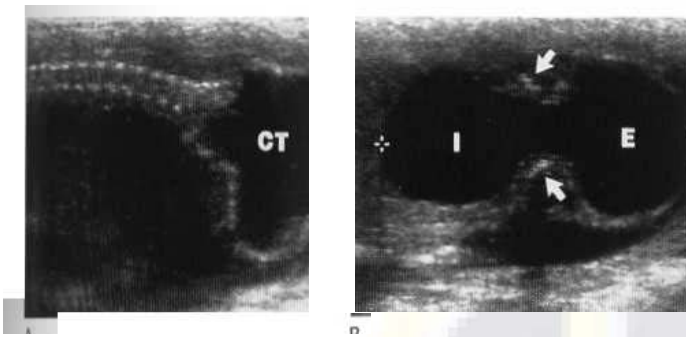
Sacrococcygeal teratoma: longitudinal (A) and transverse (B) images. CT = cystic teratoma at lower end of spine; f and E = intra- and extrapelvic components respectively; arrows = pelvic bones.
